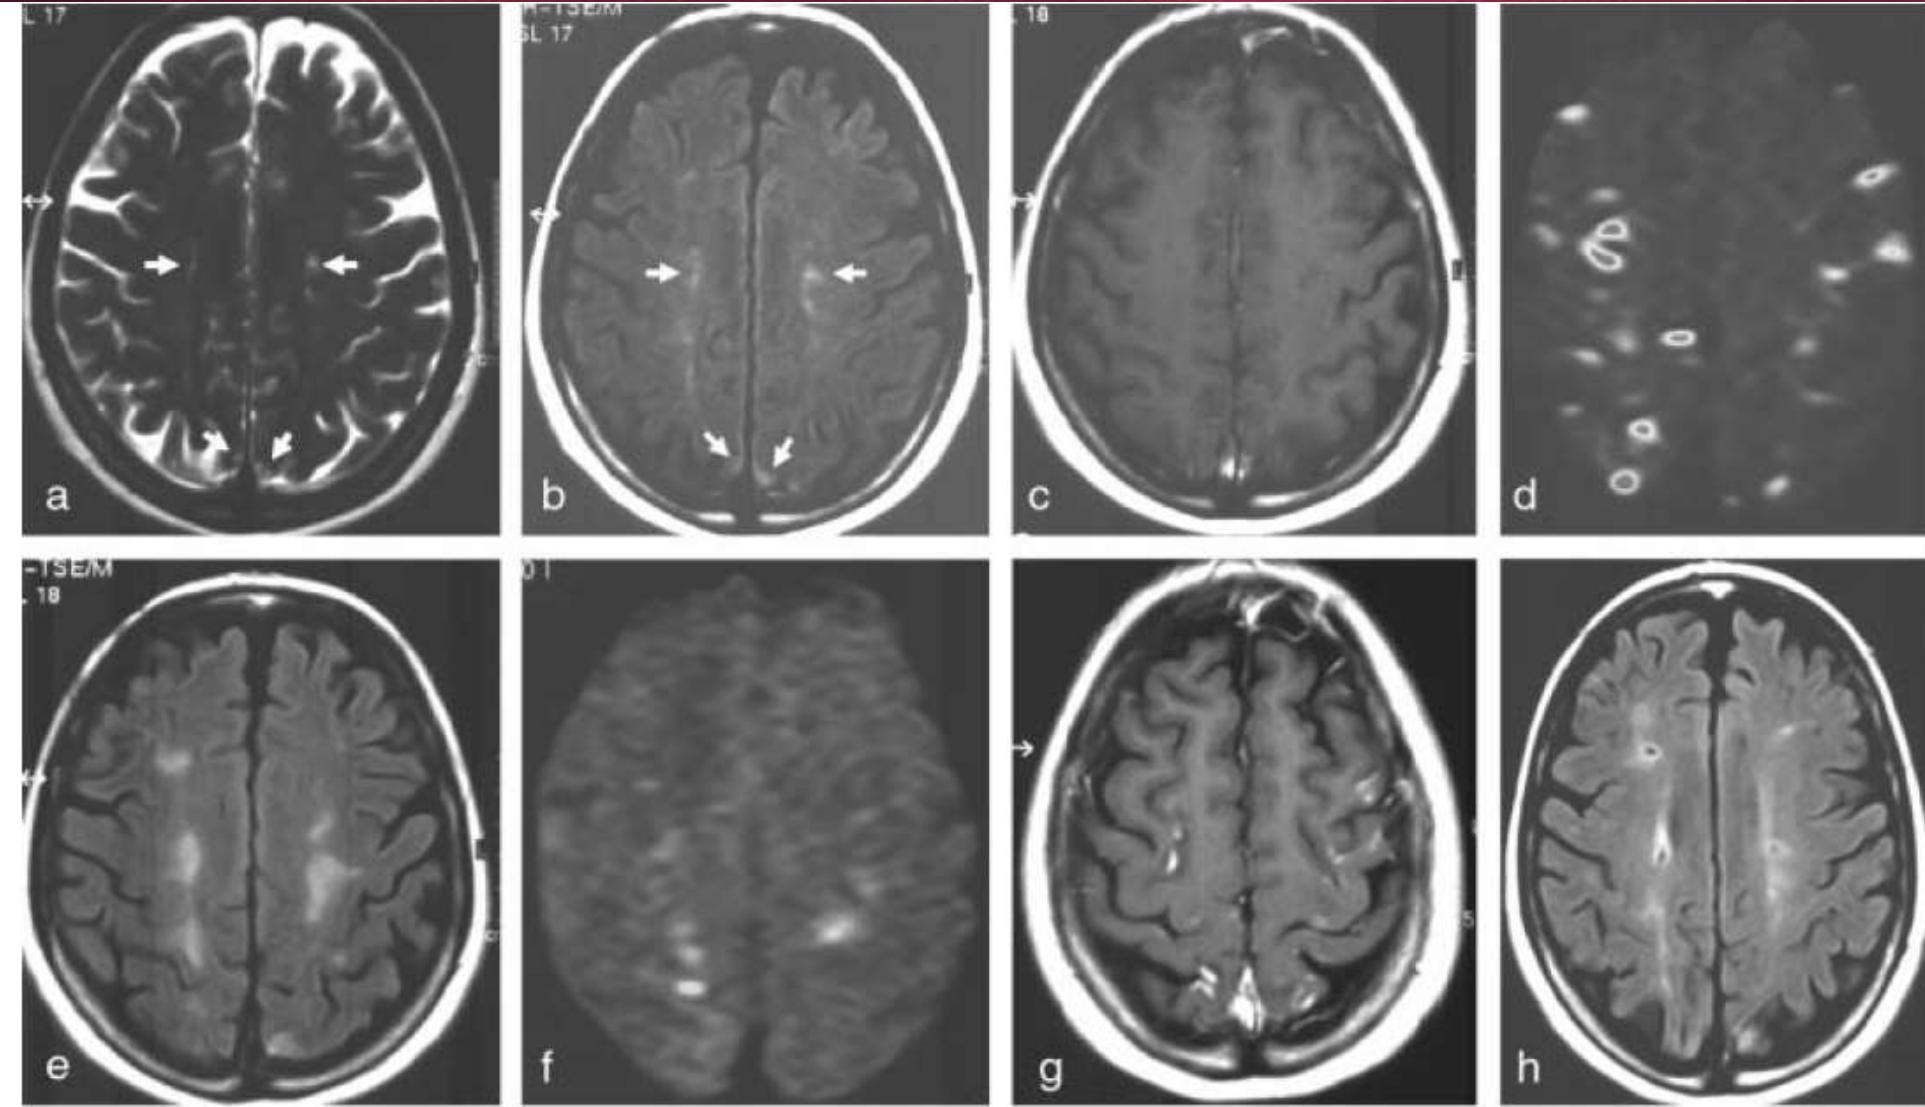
Evolution of brain lesions in trichinosis. A. TSE T2W axial image at admission shows several cortical and subcortical milimetric nodular lesions with slight signal increase (arrows). B. These lesions are better seen on a TSE FLAIR T2 axial image (arrows). C. Postcontrast SE T1 axial image is normal, with no evidence of contrast enhancement. D. Isotropic diffusion-weighted (DW) image acquired at the same session reveals numerous lesions representing restricted diffusion, most of which were not present on the FLAIR T2W image. E. In a TSE FLAIR T2W axial image acquired 3 weeks later, the lesions that were evident only on DW images in the previous examination are detected with high conspicuity. F. On the DW image, many of the high signal intensity lesions seen on the first DW study disappeared, with only a few remaining. On postcontrast SE T1W image (G), slight contrast enhancement is noted in some lesions. H. Two months later, the lesions had shrunk and tiny cavities had developed within them on TSE FLAIR T2W study.
